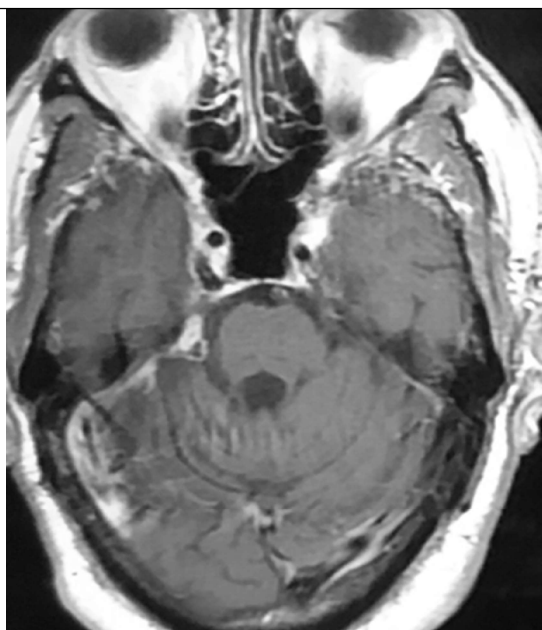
Post-operative MRI brain T1 with contrast of the same patient showing a small residual tumour.
